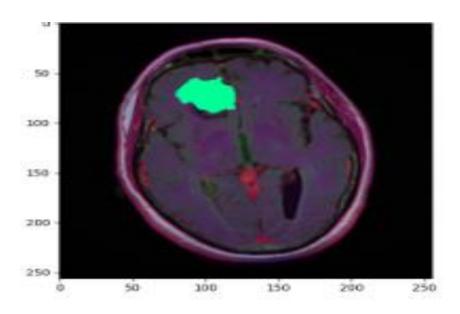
Brain MRI with predicted mask
